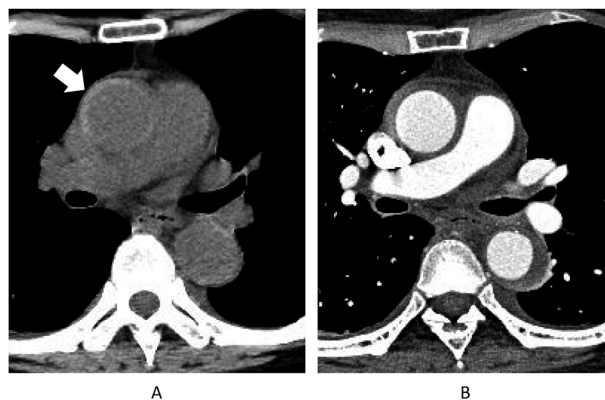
Increased density of the acute thrombus in the false lumen. Acute thrombus in the false lumen has marginally higher density than blood on the plain computed tomography (CT) (arrow) (A), whereas such high density is difficult to detect on the contrast-enhanced CT (B).
